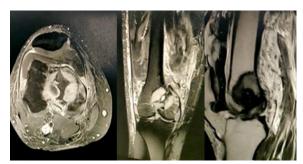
MRI knee suggestive of GCT
